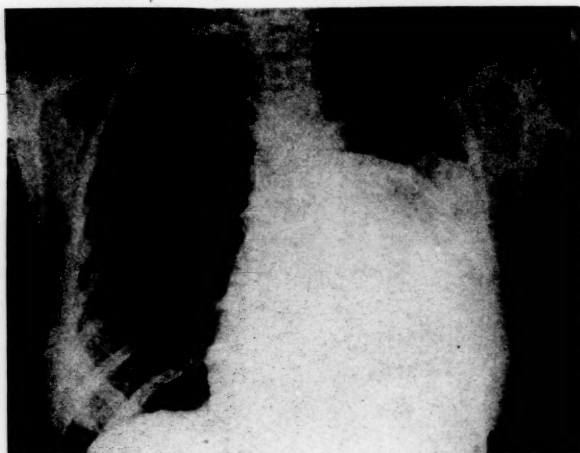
X-ray of chest on admission showing hemo-pneumothorax on left.
